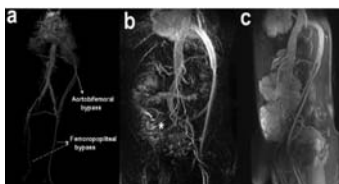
Postoperative Multislice CT view of patient three demonstrating the bilateral common iliac artery stenosis, aortobifemoral and bilateral femoropopliteal bypasses. Figure 3b: Postoperative anteroposterior MR angiographic view of patient four. \* is the aorto-right external iliac anastomosis. Figure 3c: Postoperative lateral MR angiographic view of patient four.
